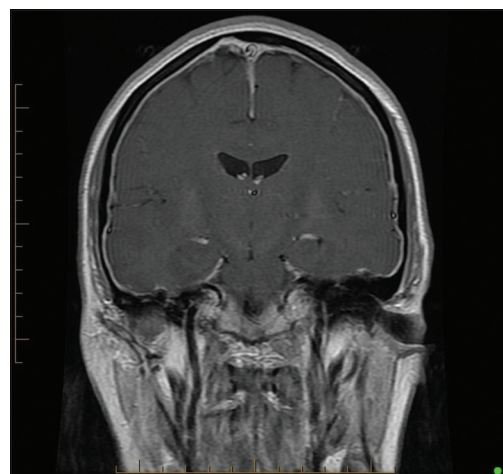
T1-weight coronal magnetic resonance imaging head postgadolinium pretreatment with diffuse dural enhancement
